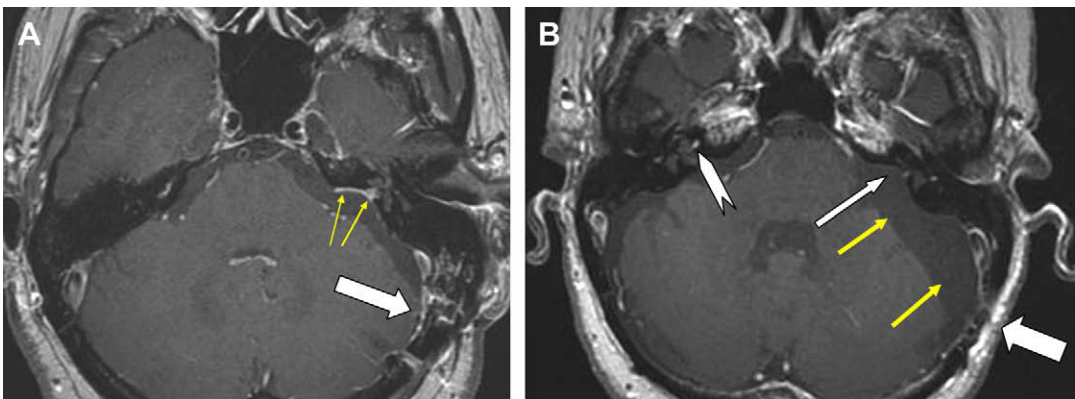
(A) Axial postcontrast T1-weighted image demonstrates typical postoperative change following AS surgery by the retrosigmoid (RS) approach. Note the craniotomy defect (white arrow), prominence of CSF along the left lateral margin of the cerebellum, and fine linear enhancement along the medial margin of the widened porous acousticus (yellow arrows). (B) Axial postcontrast T1-weighted image in a different patient following AS resection by RS approach demonstrates a craniotomy defect (thick white arrow), mild cerebellar encephalomalacia (yellow arrows), and no appreciable residual enhancement in or about the widened IAC (thin white arrow). Incidental note is made of a cochlear schwannoma on the right (white chevron).
